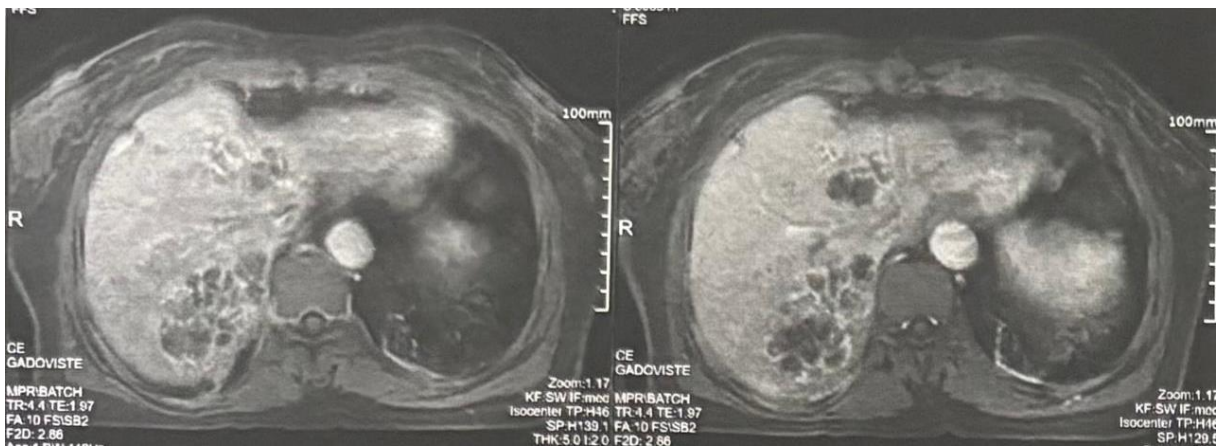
MRI images showing multiple hepatic lesions
